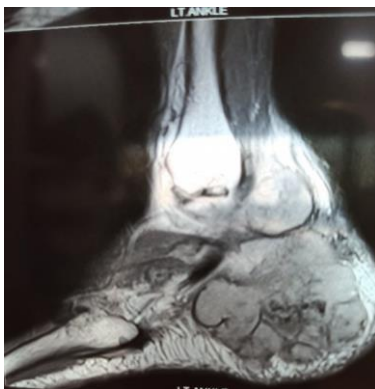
CT scan-heterogeneously hypointense on T2 showing peripheral nodular enhancement with soft tissue involvement.
